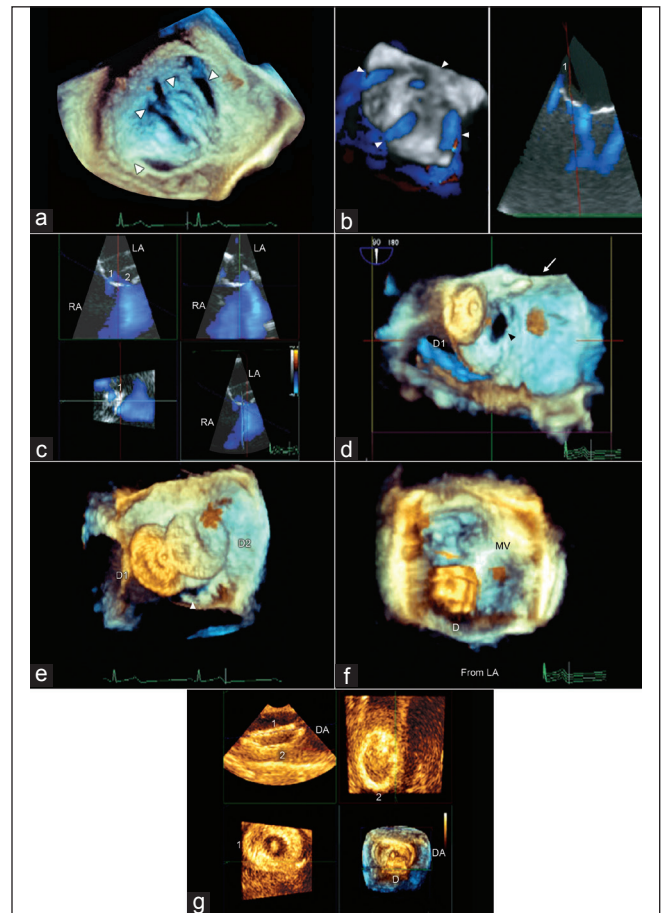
(a-g) Live/real time three-dimensional transesophageal echocardiographic assessment of device embolization during percutaneous atrial septal defect (ASD) closure. (a) The arrowheads point to multiple secundum ASD (ASD, "swiss cheese" appearance) viewed en face from the left atrium (LA). (b) Color Doppler assessment showing flow signals within the defects viewed en face (left panel). QLAB examination (right panel) showing four defects numbered 1, 2, 3, and 4. (c) QLAB examination demonstrating en face view of one of the defects (1) using color Doppler. In the upper left panel the cropping plane is positioned exactly parallel to the defect which resulted in en face viewing of the defect in the lower left panel. Subsequently the area was measured by planimetry. (d) Demonstrates the first ASD closure device (D1) in position (viewed from left atrium and anatomically correct). Arrowhead shows a large residual defect viewed en face. The arrow points to the device placement catheter. (e) The second ASD closure device (D2) in position, partially overlapping D1 (viewed from left atrium and anatomically correct). Arrowhead shows the presence of one of the two significant residual defects. (f) Embolization of one of the closure devices (d) to the LA. (g) The device (d) in the proximal descending thoracic aorta (DA) after percutaneous manipulation from the iliac artery. 1 and 2 denote the right and the left atrial sides of the device, which are viewed en face in the left lower and the right upper panels (MV: Mitral valve; RA: Right atrium). Reproduced with permission from Wei J, Hsiung MC, Tsai SK, et al. Atrial septal occluder device embolization to an iliac artery: A case highlighting the utility of three-dimensional transesophageal echocardiography during percutaneous closure. *Echocardiography* 2012;29:1128-31
